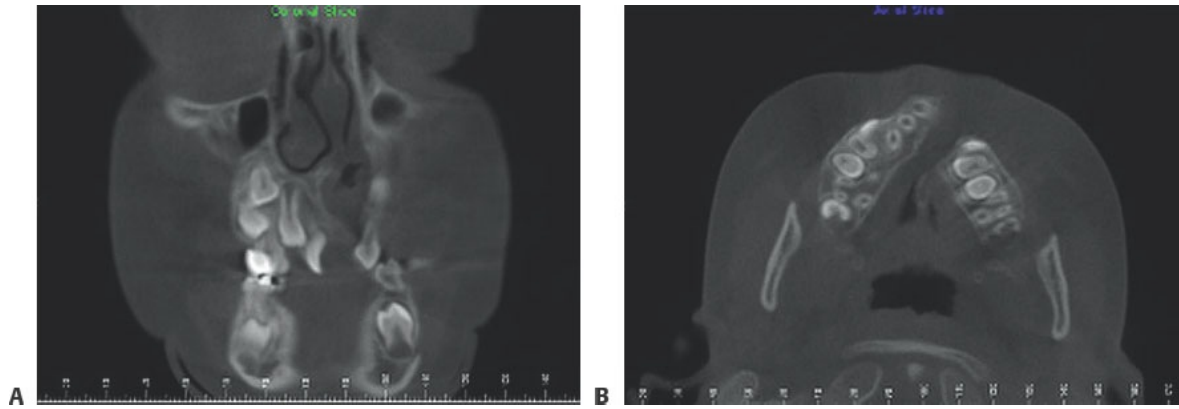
• A,B. Cone-beam CT demonstrating the pyramidal defect of the alveolar cleft.
